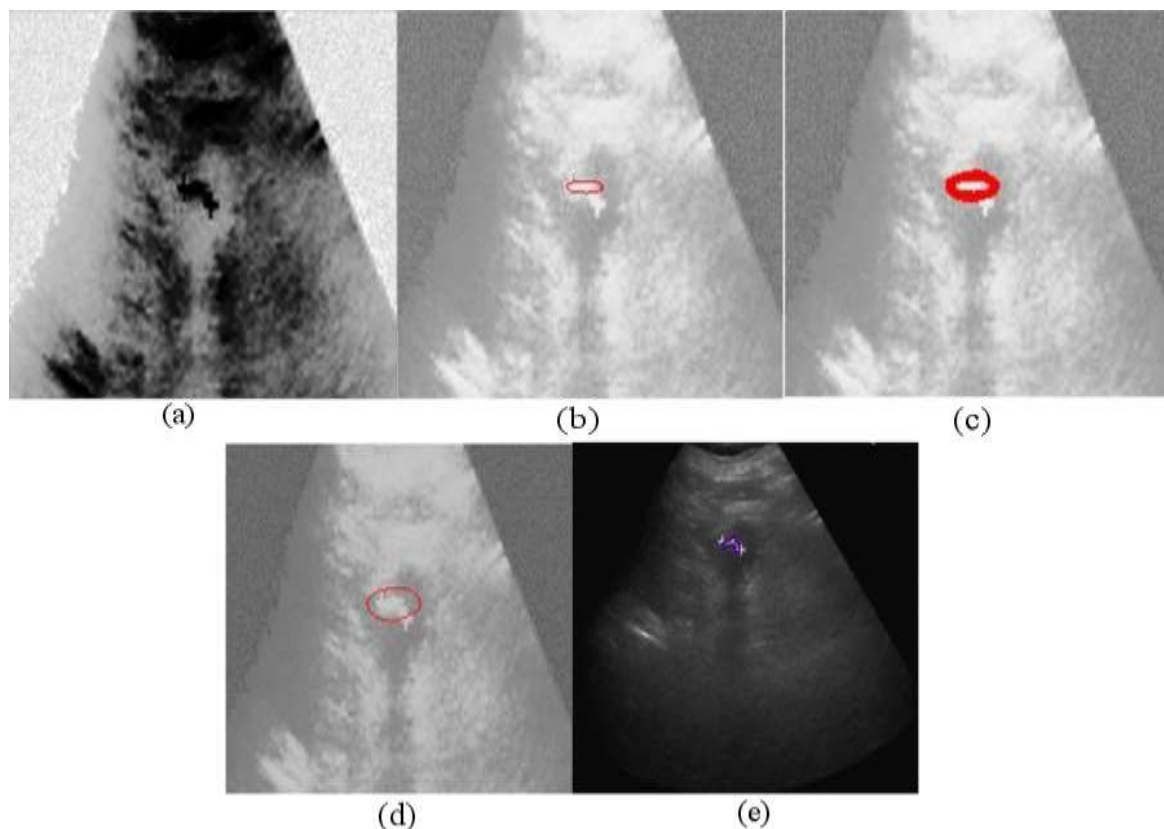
Segmentation of single-stone kidney using GVF model: (a) Denoised single-stone ultrasound image of kidney (b) User-defined initial contour (c) Deformed intermediate image (d) Finally segmented image (e) Manual annotation by medical expert
